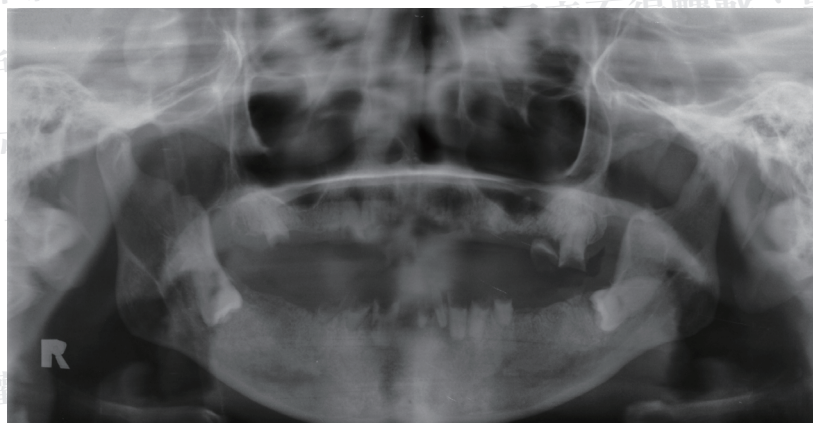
Panoramic x-ray showing multiple residual roots, impacted lower third molars, and resected bilateral coronoid process.
